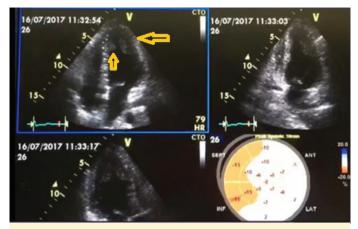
Cardiac echocardiography images showing thickening in the apical and apicolateral regions of the left ventricle.
